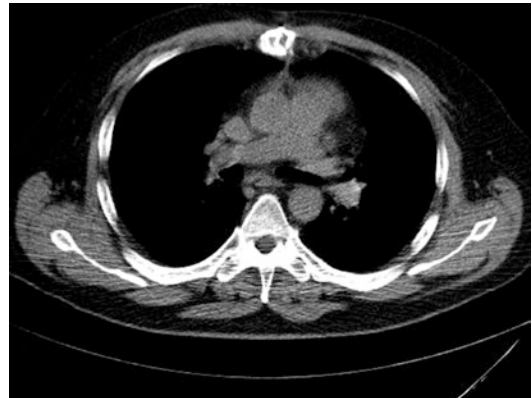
Postoperative CT scan (2 months) pulmonary trunk and branches without any thrombotic material
